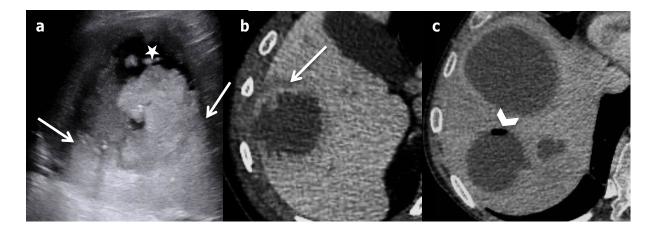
Hepatic pyogenic abscesses in a 49-year-old male patient. (a) Ultrasonography shows a large hypoechoic lesion, heterogeneous, with anechoic parts (star) and increased through-transmission (arrows) confirming its cystic nature. (b and c) Axial venous portal-phase computed tomography shows multiple abscesses appearing as cystic masses, with a specific sign: the double target (arrows). Note the bubble of gas in one of them (arrow-head).
